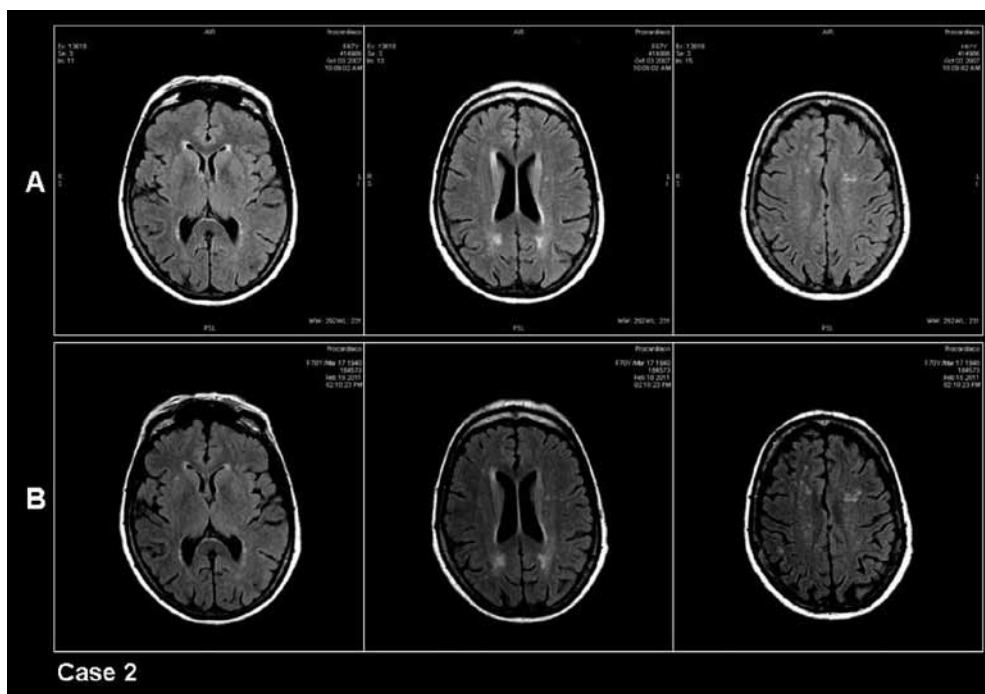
Case 2. MRI-FLAIR acquisition of three representative axial sections that show WMH burden. A: mFazekas score = 1; B: mFazekas score = 1.
